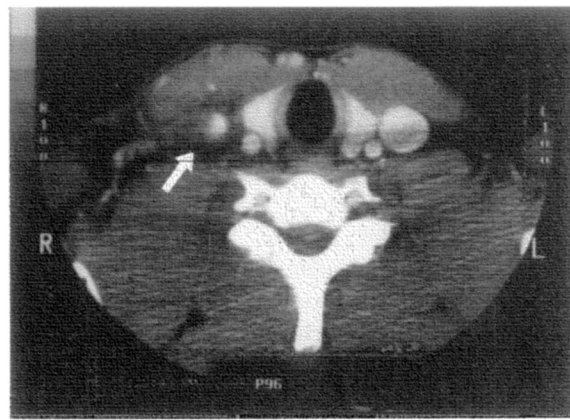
CT scan of the neck showing thrombus occluding the right internal jugular vein (arrow).
